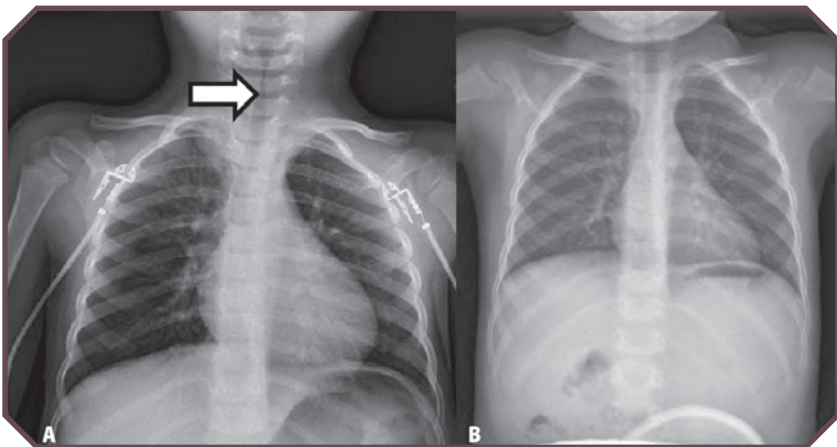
Croup. A. Anteroposterior (AP) chest radiograph in a 4-year-old girl demonstrates subglottic narrowing (arrow). B. Note the normal trachea in the same child on a previous AP radiograph.
